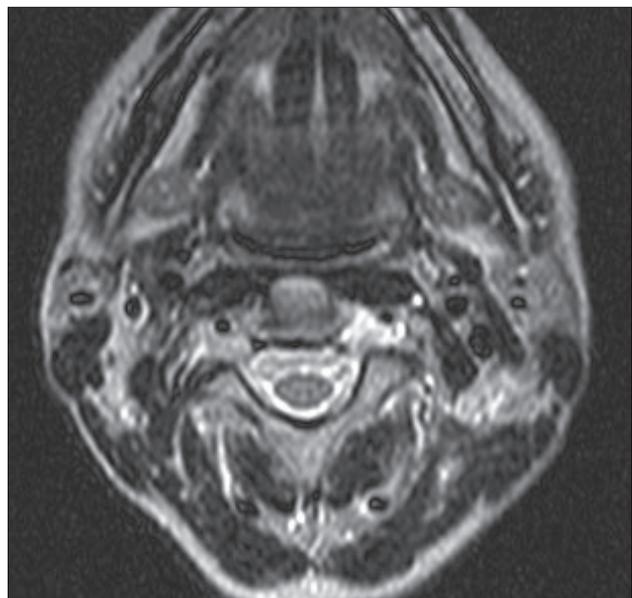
MRI of the neck after operation. Condition after the vagus nerve neurofibroma extirpation reg colli 1.dx.
